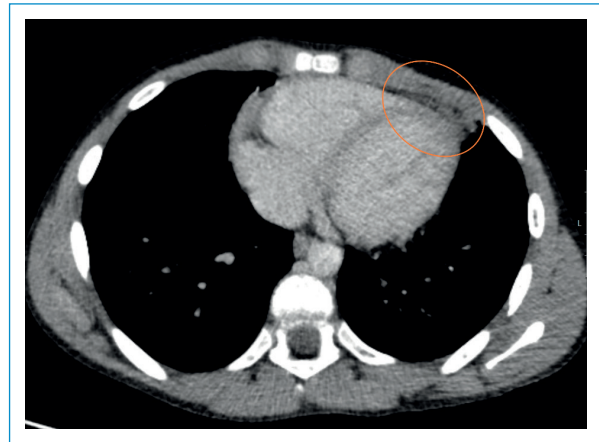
Chest CT confirmed the presence of an ovoid heterogenous adipose mass with mild fat stranding.
